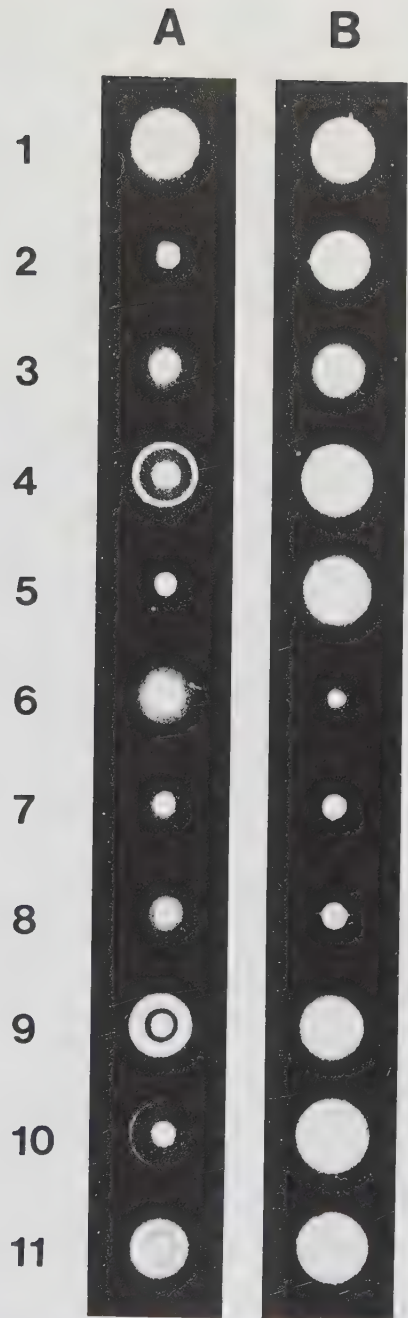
Hemolysis in gel assays using EA (A) and GpE (B). 1. Normal human serum. 2. Serum with C1q less than 5% and high amounts of C1r-C1s complexes and 3. serum with normal C1q and all C1r and C1s present in C1r-C1s-CT IA complexes from two patients with chronic urticaria. 4-11. Pathological sera from patients with: 4. Rheumatoid arthritis. 5. Myeloma. 6 and 7. Acute glomerulonephritis. 8. Membranoproliferative nephritis. 9. Primary biliary cirrhosis. 10. Acute cholecystitis with cholestasis. 11. Crohn's disease.
